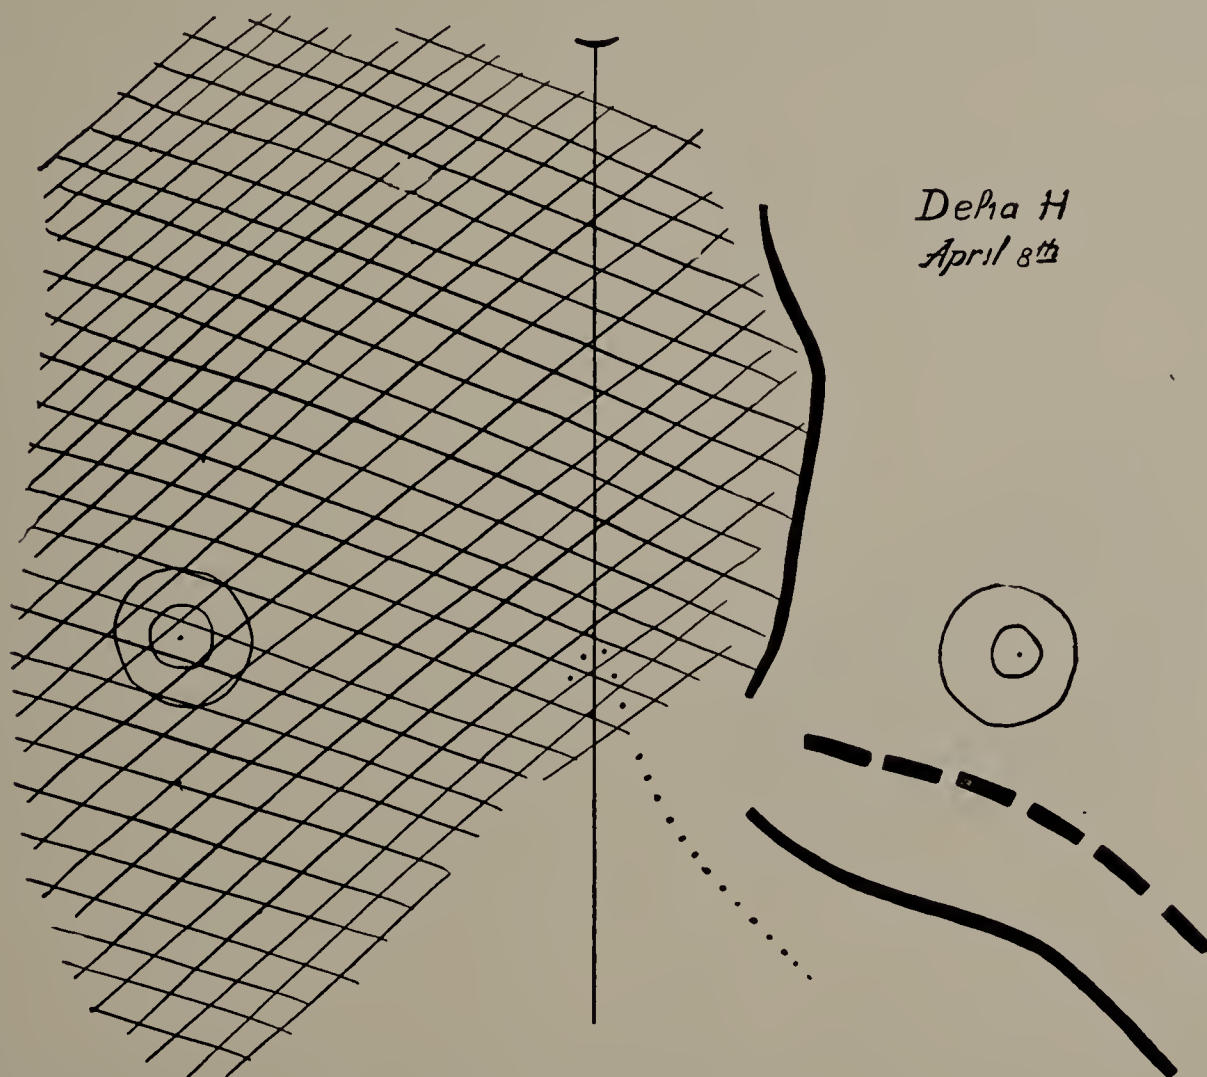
Delia H. Second X-ray tracing, after a litre of air had been withdrawn from the left side. The diaphragm was higher, had some excursion during respiration, and the border of the light area was farther to the left of the median line than at the first examination. (Size one-third.)
